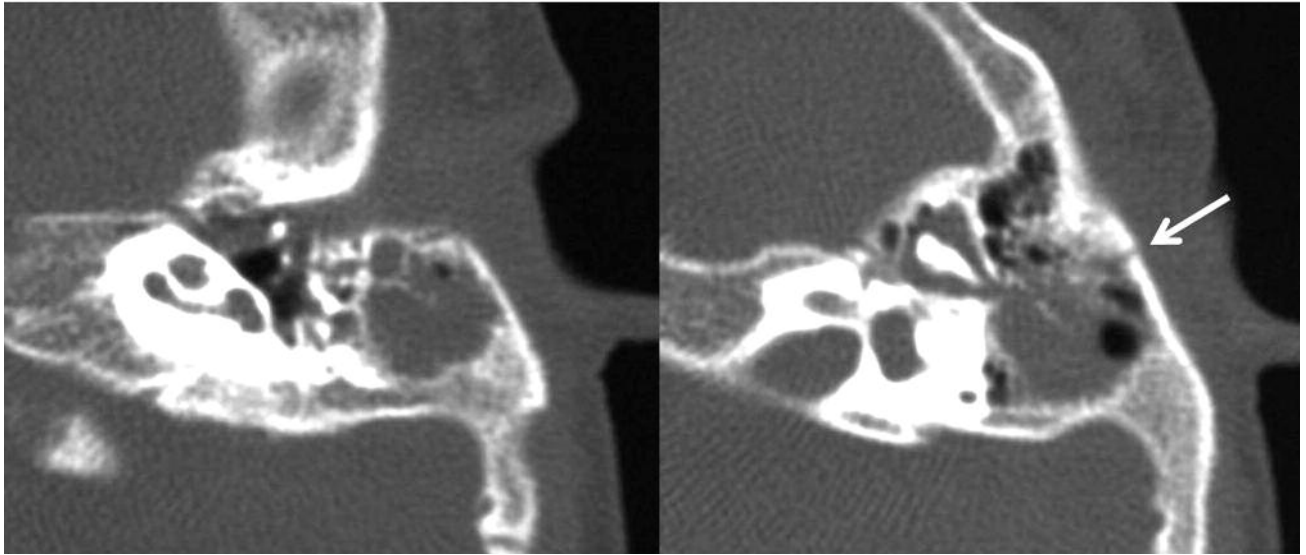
Axial temporal bone computed tomography performed immediately after the trauma demonstrated soft tissue density in the middle ear cavity and a minor fracture line on the surface of temporal bone (arrow). There was no other fracture or ossicular dislocation.
